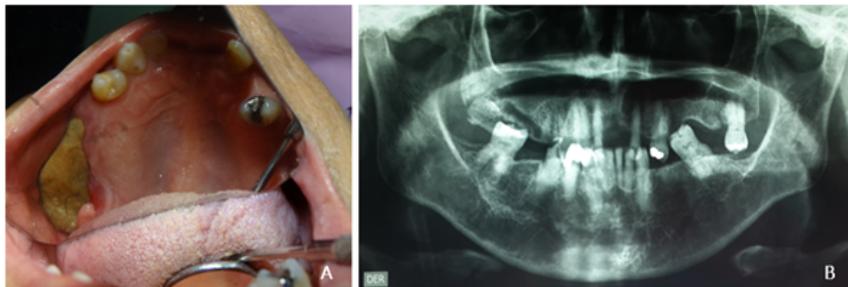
Preoperative Photographs: a. Intraoral, where the presence of bone exposure in the posterior alveolar region of the right maxilla that extends to the tuberosity was evidenced b. Panoramic Radiography, where the presence of bone sequestration is evident on the right posterior alveolar ridge of the maxilla, causing a segment fracture.
